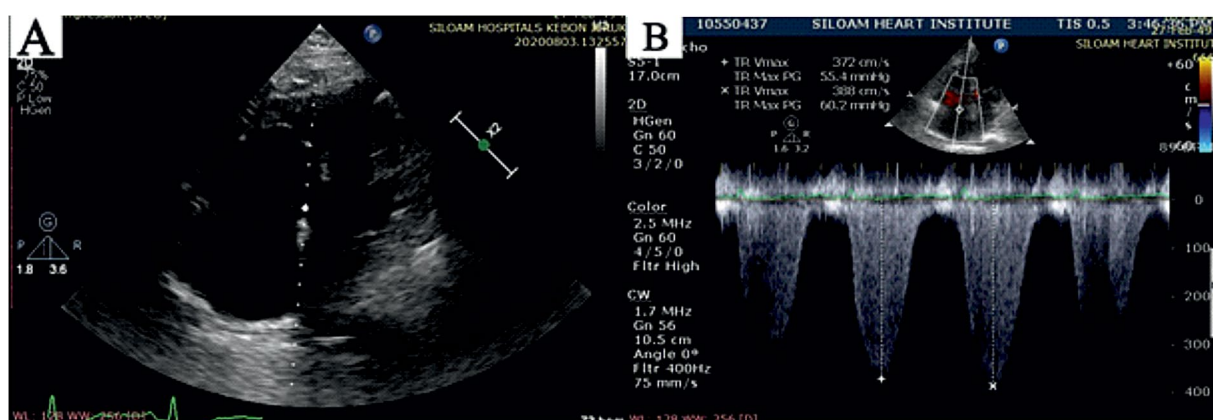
Echocardiography findings. A. Remarkable right ventricular enlargement seen from the apical 4-chamber view. B. Maximum velocity of the tricuspid regurgitation was around 3.8 m/s, indicating the tricuspid valve gradient of 60 mm Hg
